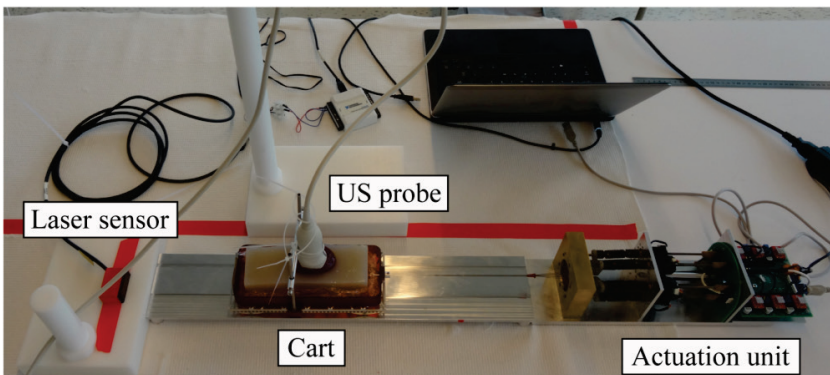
Experimental setup for the ex vivo evaluation. Experimental setup with the actuation unit, the aluminium cart on with a box containing the tissue sample, the ultrasound probe (US), and the laser distance sensor.
